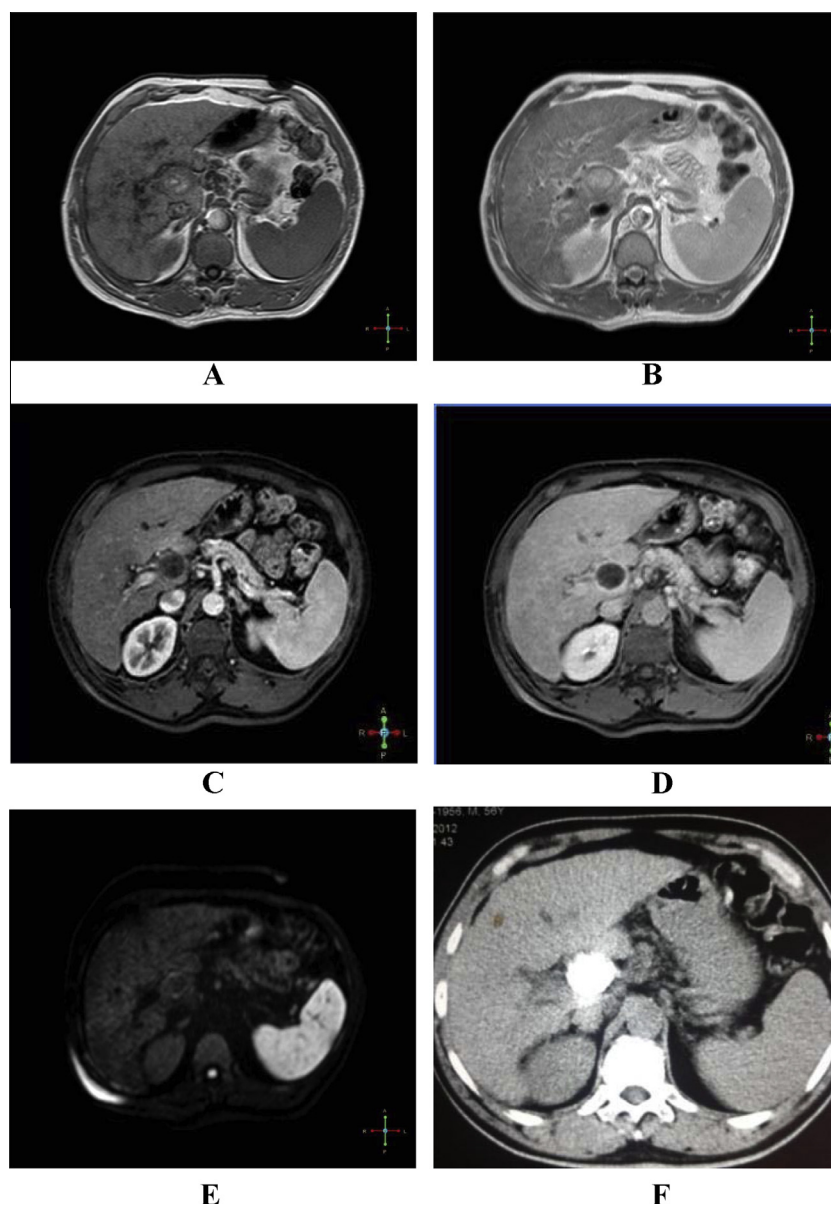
complete ablation of caudate lobe HCC. (A) Axial T1 FFE of 56 year old male showing heterogenous signal intensity of a caudate lobe chemo-embolized HCC. (B) Axial T2 SSh of the same patient showing central core of high signal intensity with peripheral rim of low signal intensity. (C) Axial early arterial phase of T1 THRIVE showing faint peripheral rim enhancement. (D) Axial post contrast T1FFE showing progressive increase of the uniform peripheral rim of enhancement. (E) Axial respiratory triggered diffusion weighted image (b value 1000) showing faint uniform peripheral rim of high signal intensity. (F) Non contrast CT of the same patient showing dense lipiodol uptake by the tumor.
